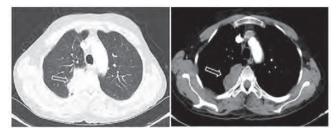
Thorax computed tomography images showed a lobulated mass lesion 55×34 mm in diameter at the posterior segment of the upper lobe of the right lung (white arrows).
